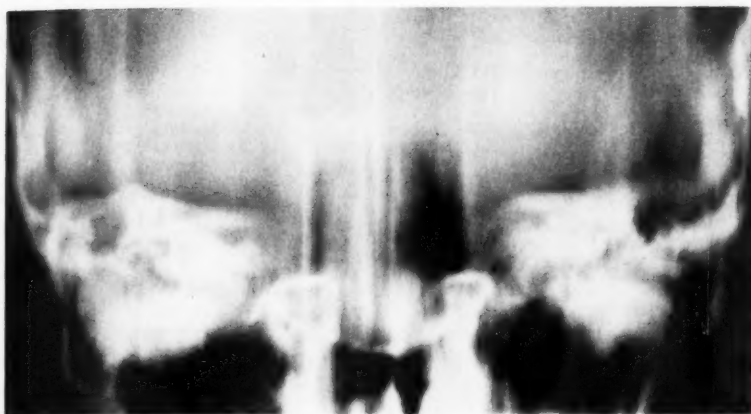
A forty-year-old female with a right chronic middle-ear infection was found to have a sclerotic mastoid on preliminary roentgen examination. A fronto-occipital view showed a poorly defined defect in the region of the right mastoid antrum.
